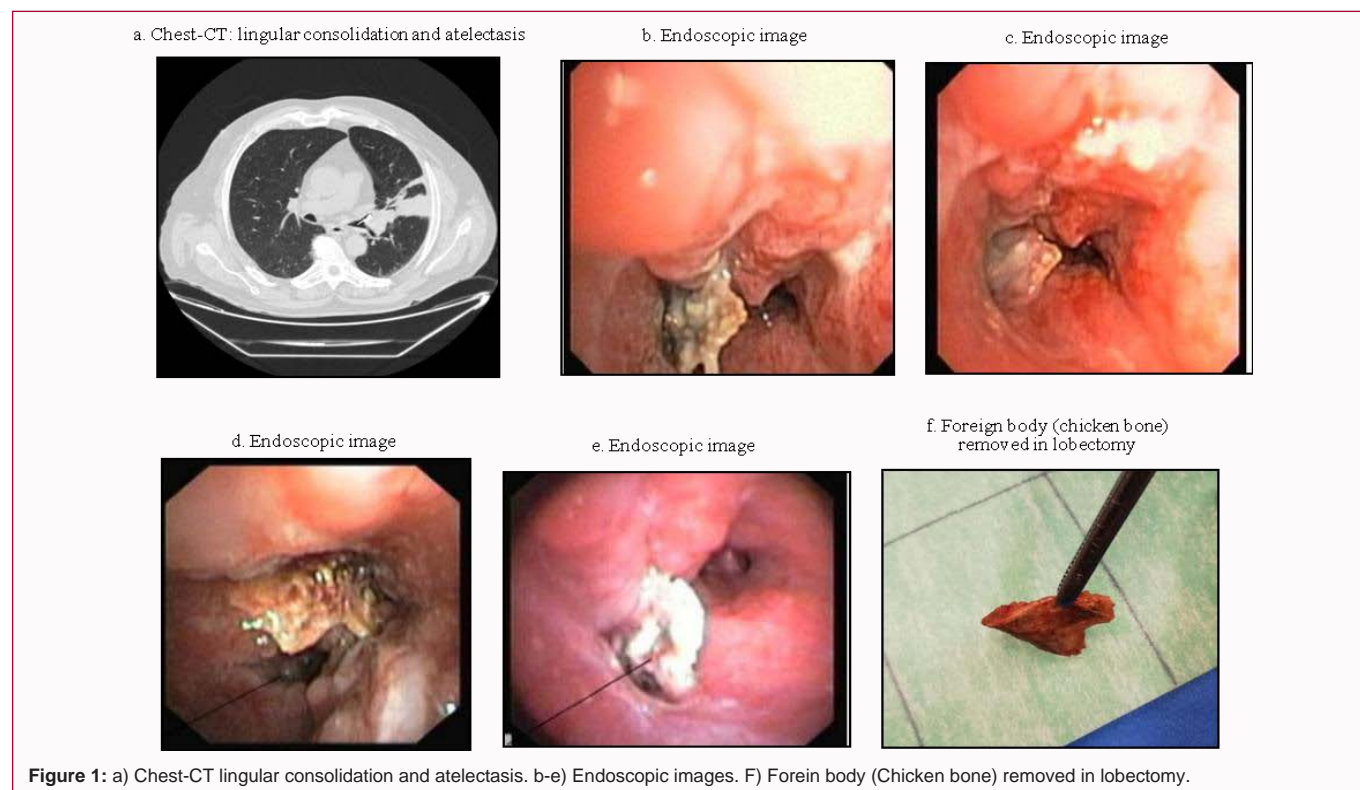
a) Chest-CT lingular consolidation and atelectasis. b-e) Endoscopic images. F) Foreign body (Chicken bone) removed in lobectomy.
